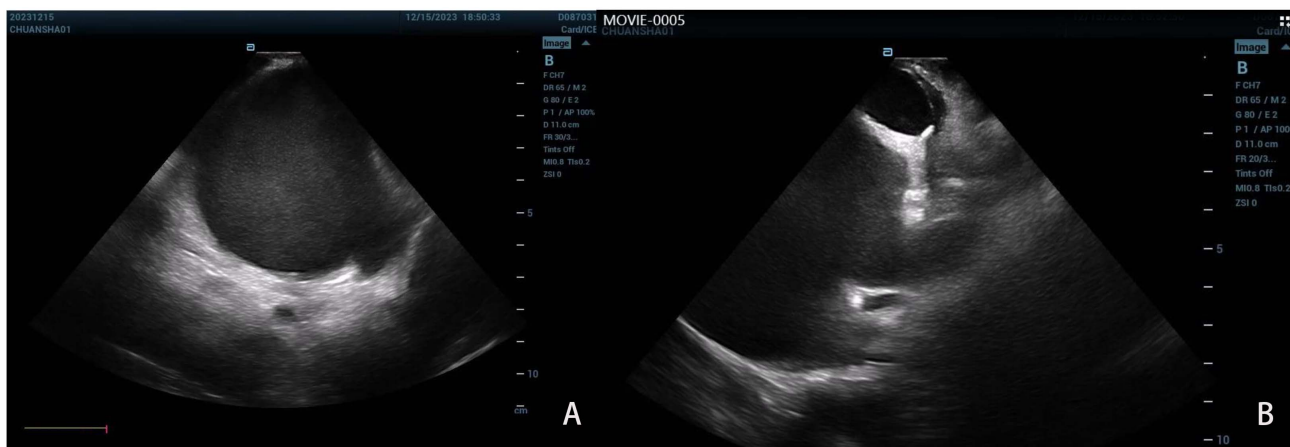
Intracardiac ultrasound was used to detect left atrial and left atrial appendage thrombus. (A) Intracardiac echocardiography (ICE) exploration of the right atrial septum, verifying the absence of a thrombus in the left atrial appendage orifice. (B) ICE exploration of the right ventricular outflow tract, verifying the absence of a thrombus within the left atrial appendage body.
